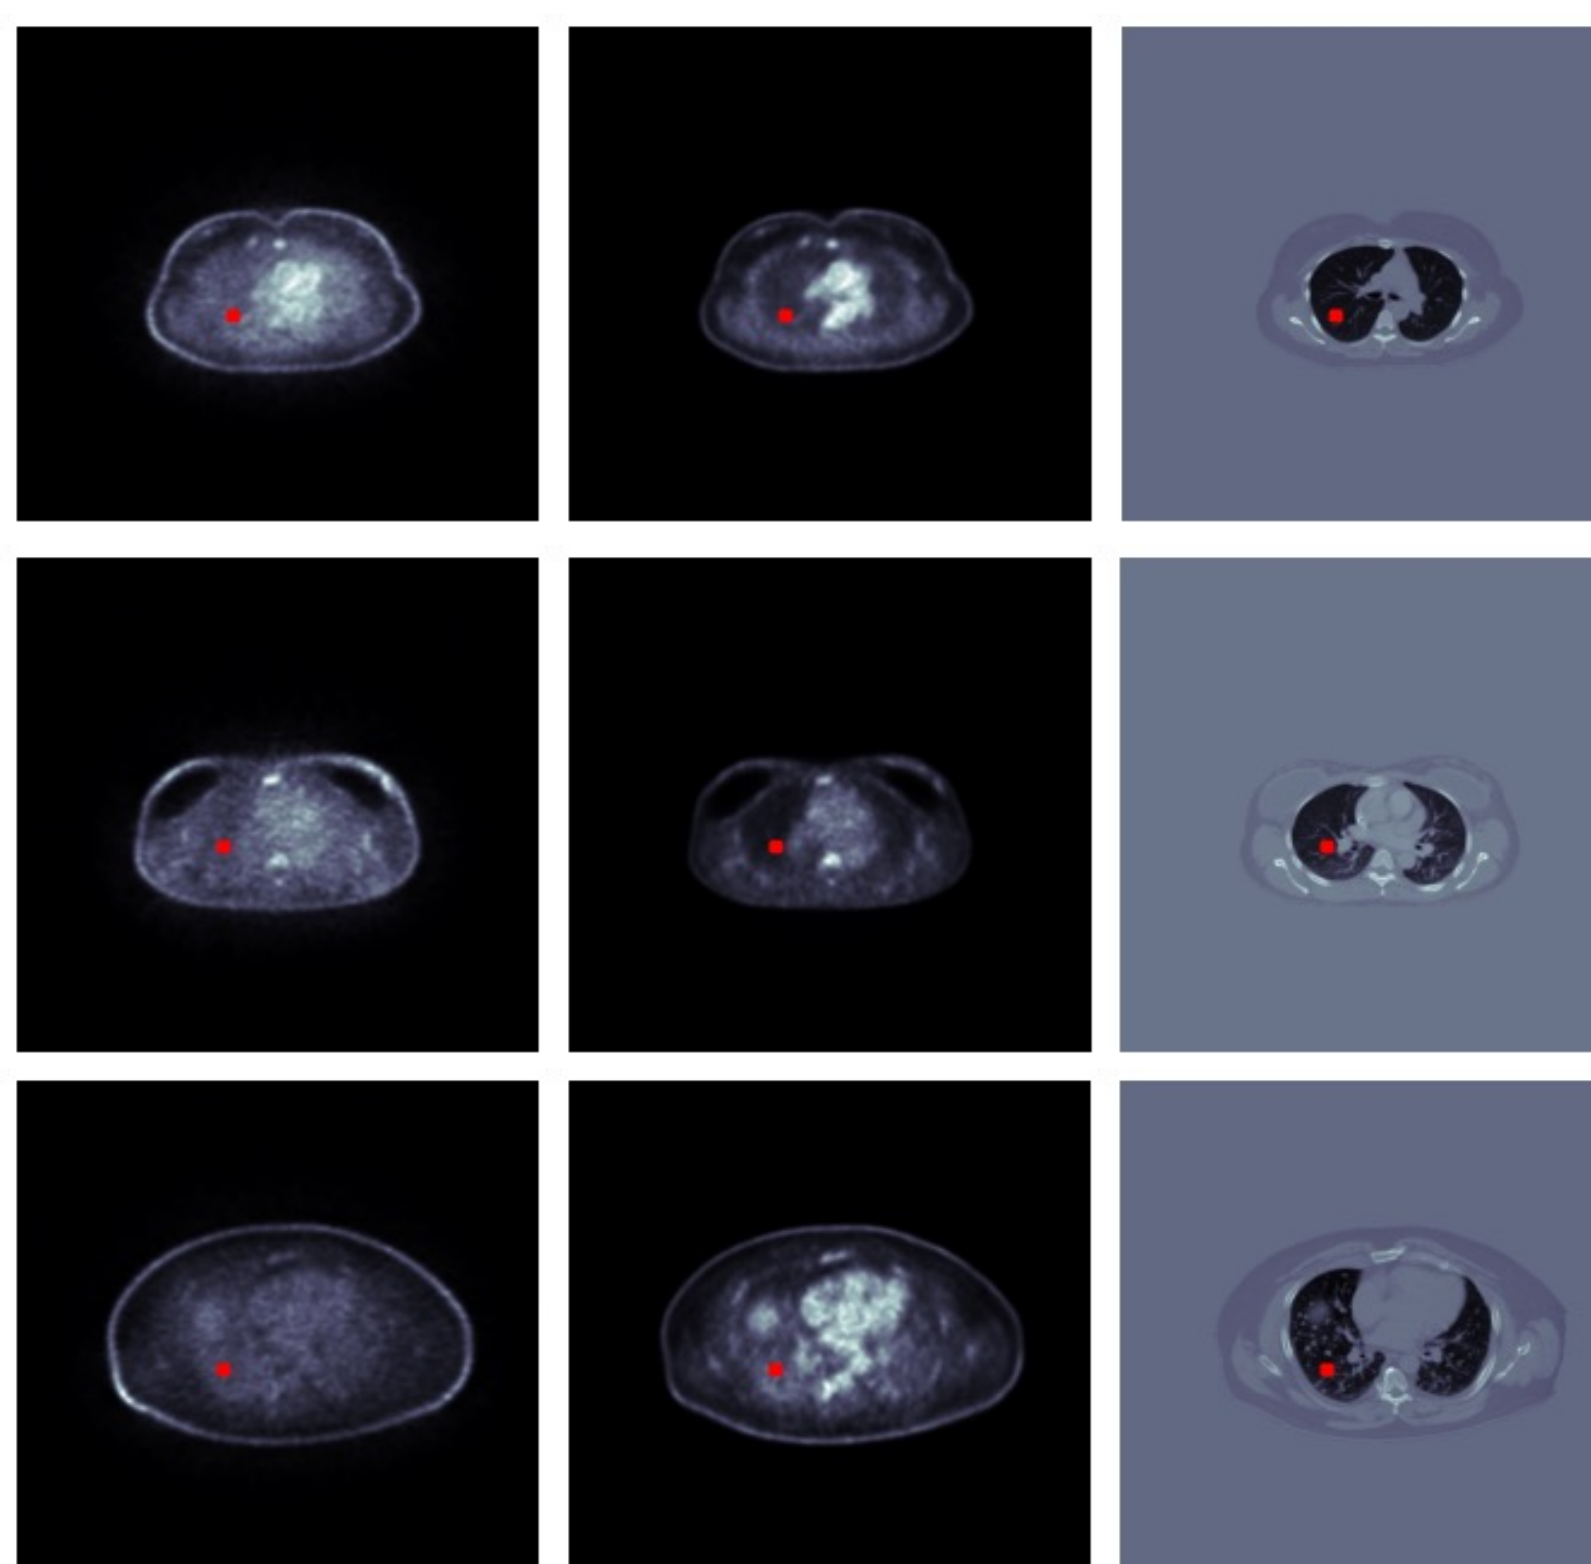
Left Column: PET with no Attenuation Correction. Middle Column: PET with Attenuation Correction. Right Column: CT with Attenuation Correction. Line profiles were carefully tested to ensure it will pass through the posterior left lung in the thoracic slices. Plotted in red are the line profiles as they pass through lung PET and CT scans of three different patients, each with different body sizes.
